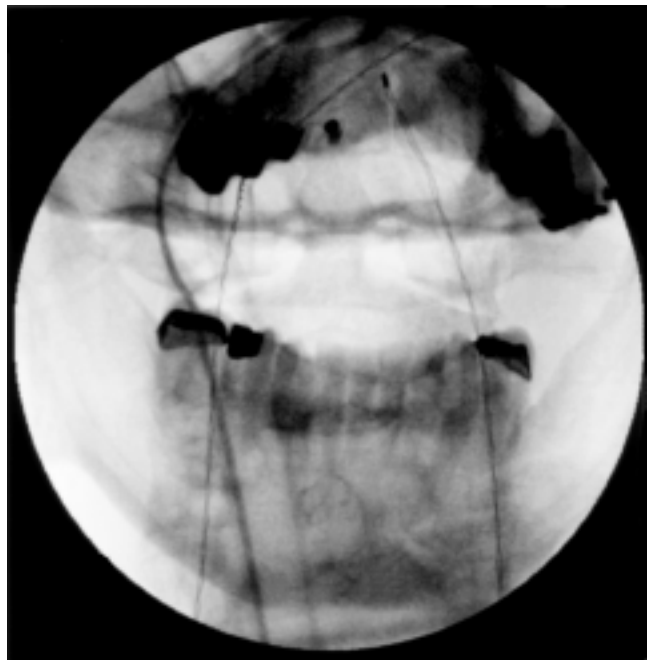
Open-mouth x-ray film obtained in the patient affixed in the headholder, showing an unencumbered view of the odontoid process.
